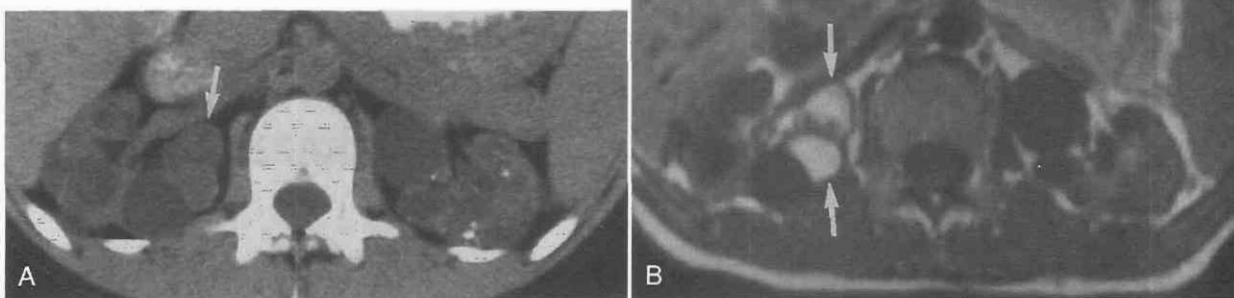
Hemorrhagic cysts in acquired renal cystic disease. *A*, Unenhanced CT scan shows multiple bilateral fluid-density cysts with cyst wall calcifications. An area (arrow) located medially in the right kidney was considered suspicious for a neoplasm. *B*, T1-weighted (TR = 500 msec, TE = 15 msec) spin-echo MR image shows that most cysts have low signal intensity. However, two lesions (arrows) located medially in the right kidney have a high signal intensity, which persisted on T2-weighted images (not shown), findings consistent with cyst hemorrhage.
